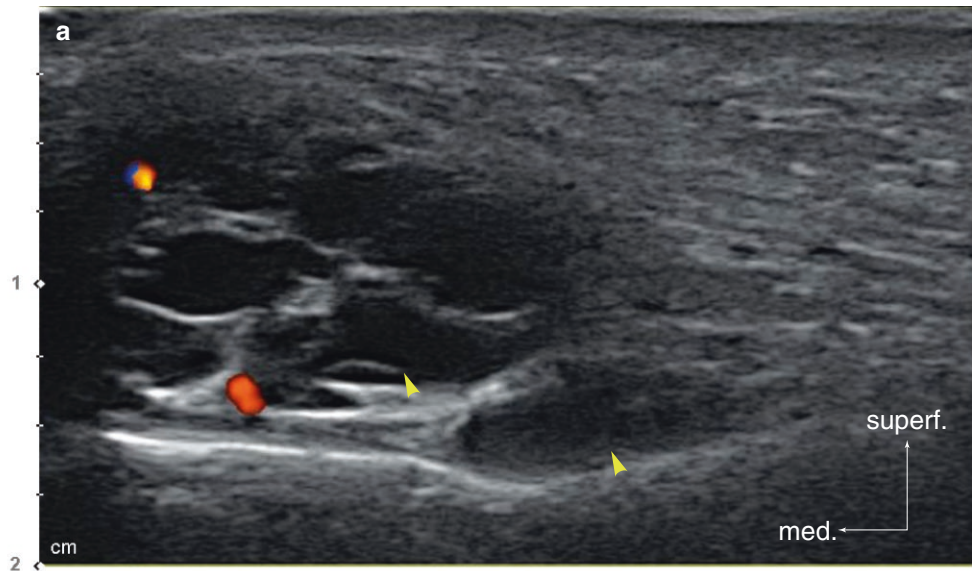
Ultrasonography-guided HA filler removal above the silicone implant underneath the nasolabial fold, B mode (transverse view, 15 MHz by linear transducer) (yellow arrowheads: HA filler, white arrowhead: injection needle). (Published with kind permission of © Ji-Soo Kim 2020. All Rights Reserved)
